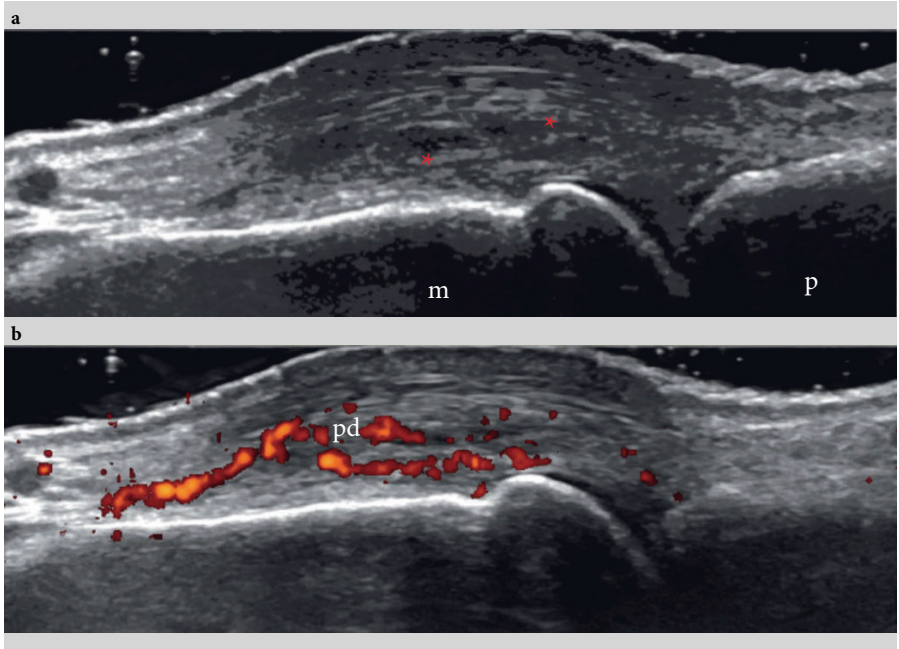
Ultrasound in early rheumatoid arthritis. In this longitudinal dorsal ultrasound scan of a metacarpophalangeal joint of a patient with early rheumatoid arthritis (RA), the grayscale (a) change and power Doppler signal (b) suggest inflammatory arthritis disease activity. *synovial hypertrophy. m, metacarpal head; p, proximal phalanx; pd, power Doppler. Reproduced with permission from University of Leeds, UK.
